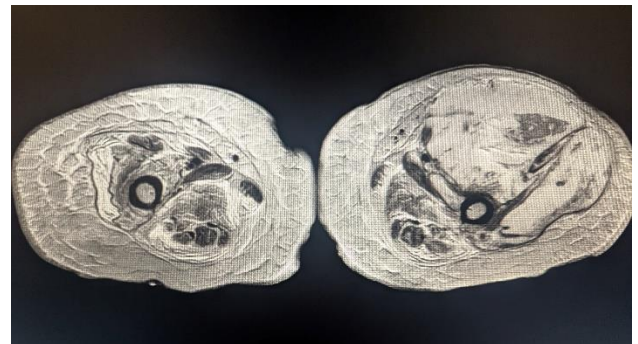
Axial section of bilateral thigh showing collection (T2 MRI).
